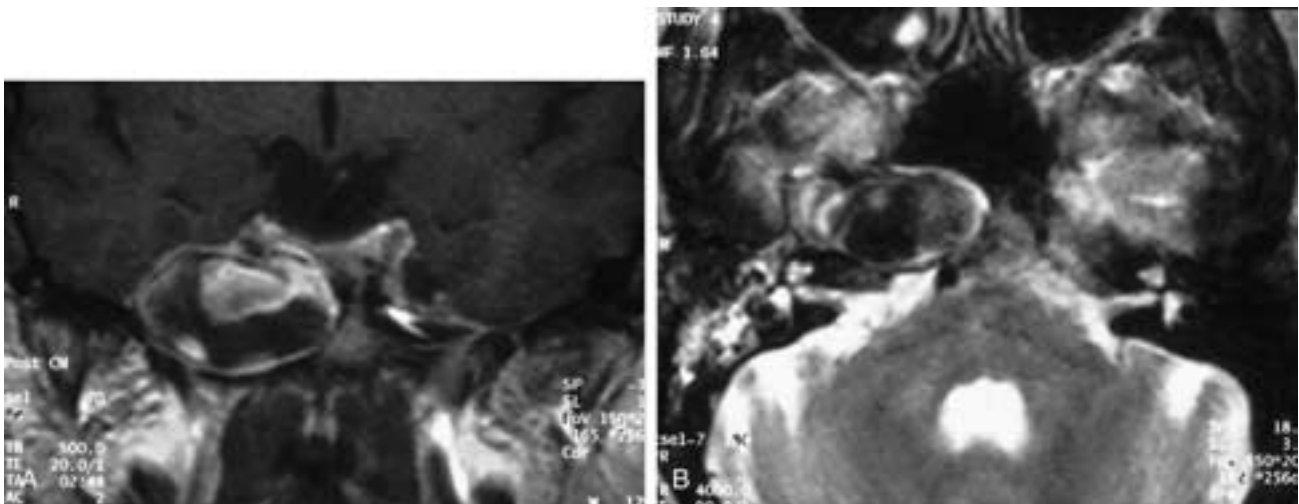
Petrous carotid aneurysm. A, Coronal T1-weighted postcontrast image shows partial thrombosis of the enlarged aneurysm of the petrous apex. Areas of bright signal represent enhancement indicating flow. B, Axial T2-weighted image shows the low signal of hemosiderin within portions of the aneurysm. Note the fluid in the middle ear and mastoid due to obstruction of the eustachian tube.
